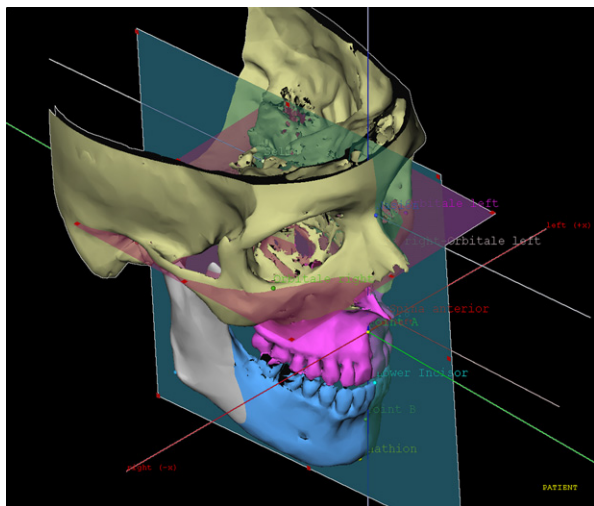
Cephalometry can be performed on the 3D skeletal model formed from the CBCT image. This allows the user to define landmarks, lines, planes, and measurements.
